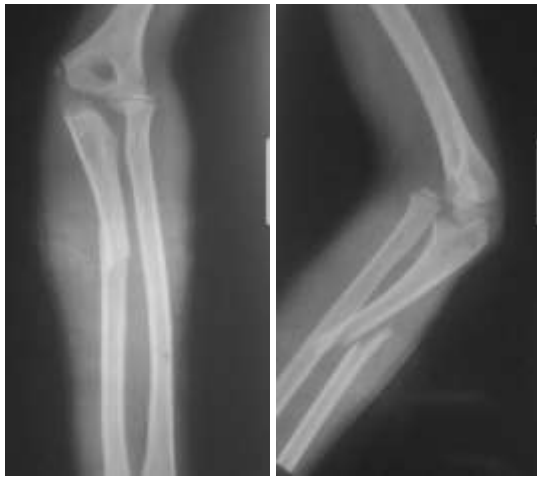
Anteroposterior and lateral radiographs of the forearm showing Monteggia fracture dislocation.
